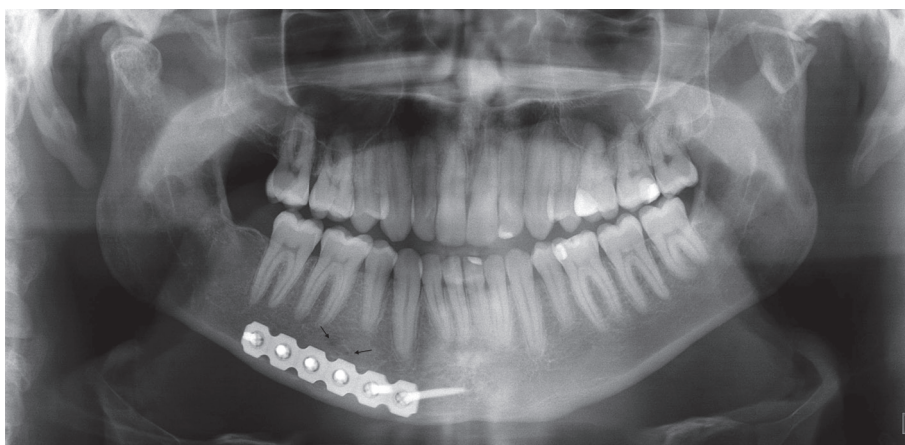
Postoperative panoramic radiography showing only two mental foramina
